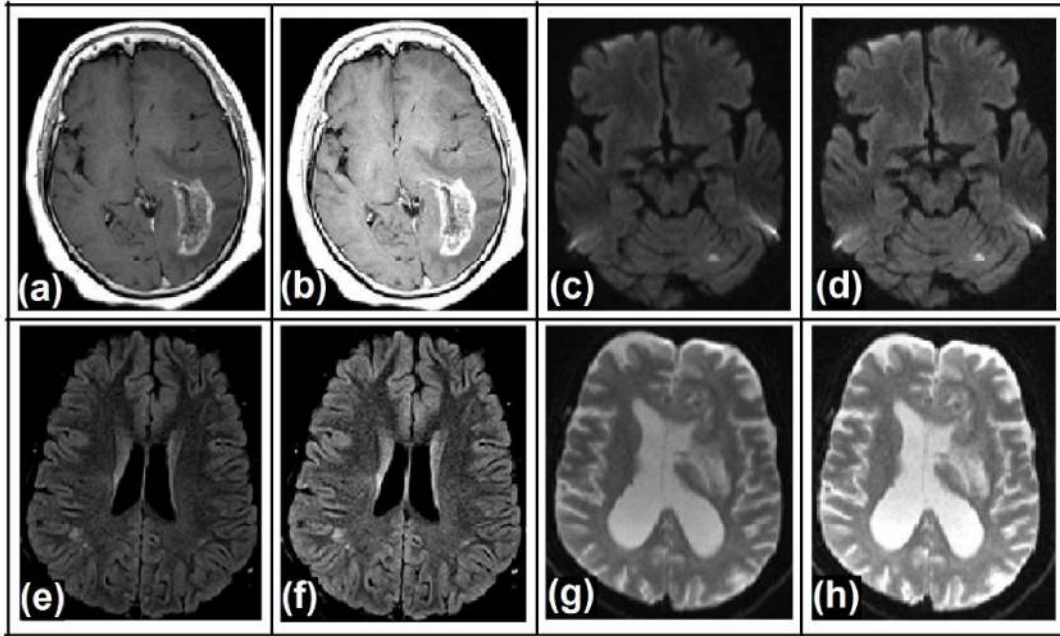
Different MRI sequences of abnormal and healthy subjects (a) T1 weighted (Test image 1), (c) DWI (b=1000) (Test image 2), (e) FLAIR (Test image 3), (g) T2 weighted (Test image 4) and (b, d, f and h) respective MOBA optimization based SR processed image
